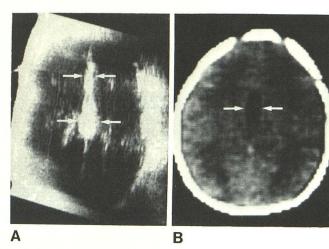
A, Axial sonogram through parietal bone in patient with lipoma of corpus callosum. Echogenic lipoma (*arrows*) in midline extends from frontal area to area of pineal gland. B, Axial CT scan. Lipoma of corpus callosum (*arrows*) extends from pineal gland toward frontal bone.
